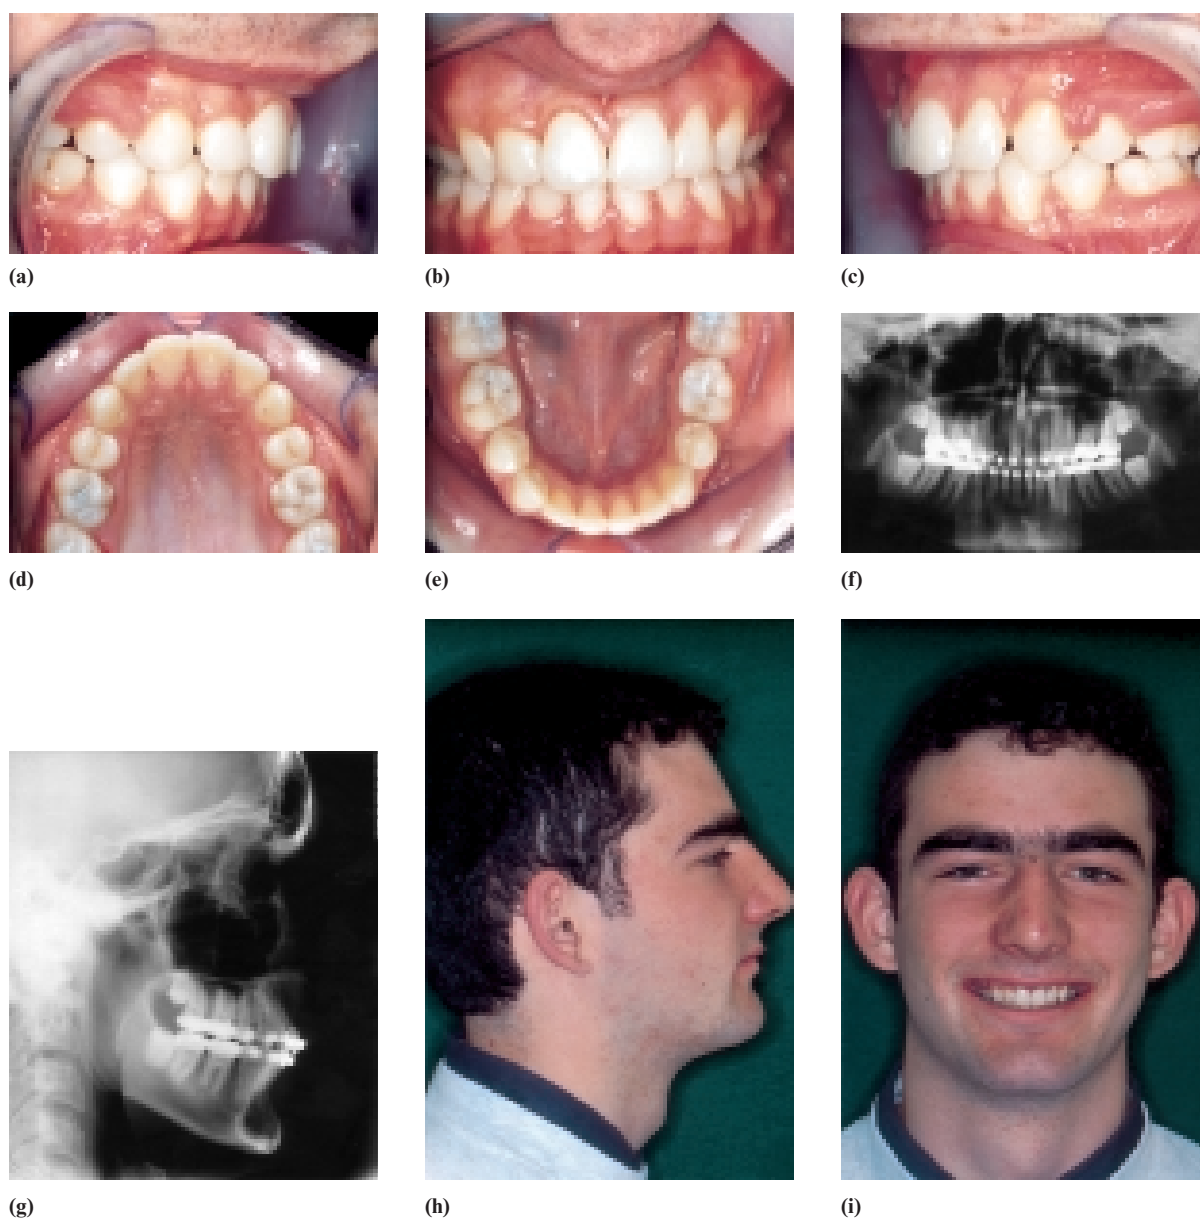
(a–l) Case report 2: post-treatment records. (a–e) Intra-oral views. (f) Panoramic radiograph. (g) Lateral skull radiograph. (h–i) Extra-oral views. (j) Cephalometric tracing. (k) Superimposition of pre-treatment (black) and post-treatment (red) cephalometric tracings on De Coster's line. (l) Maxillary and mandibular superimposition of pre-treatment (black) and post-treatment (red) cephalometric tracings on Björk's reference structures.
